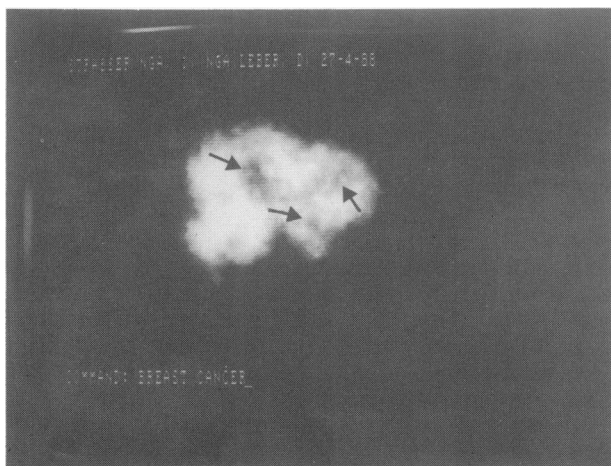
^{99m}Tc-NGA binding to the liver of a patient (L.G., 73 years, breast cancer) with liver metastasis. SPECT imaging revealed a lack of tracer uptake in the malignant area (arrows).
